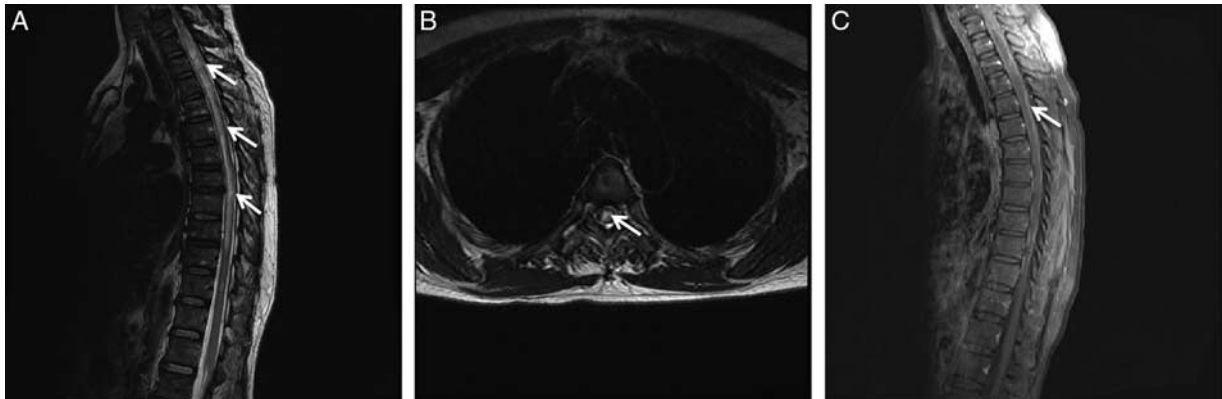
A 54-year-old woman with aquaporin-4–positive myelitis for 2 months. Spinal magnetic resonance imaging with sagittal T2-weighted image (A), axial (B), and sagittal T2 with gadolinium image (C). A longitudinal extensive T2-hyperintense lesion (arrow in A, B) involving the C4-T10 is seen. After gadolinium administration, a patchy, cloud-like contrast enhancement (arrow in C) on the axial section is observed.
